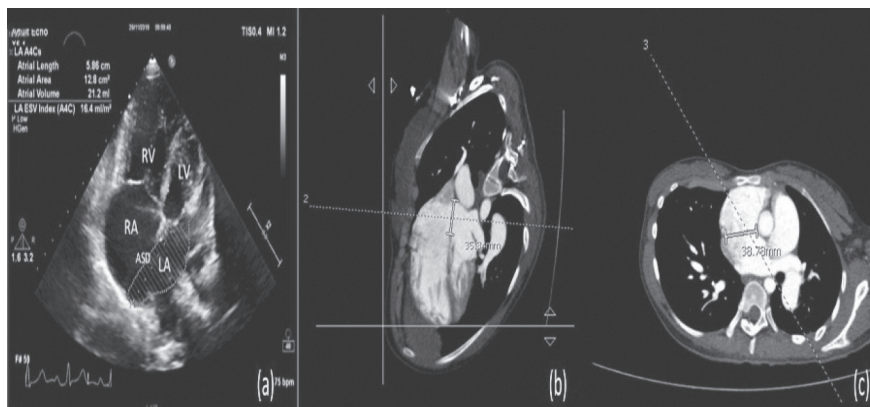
(a) Transthoracic echocardiography shows a large ASD, (b) CTA of the thoracic aorta sagittal view, and (c) axial view shows ASD size of 35.3×38.7 mm.
